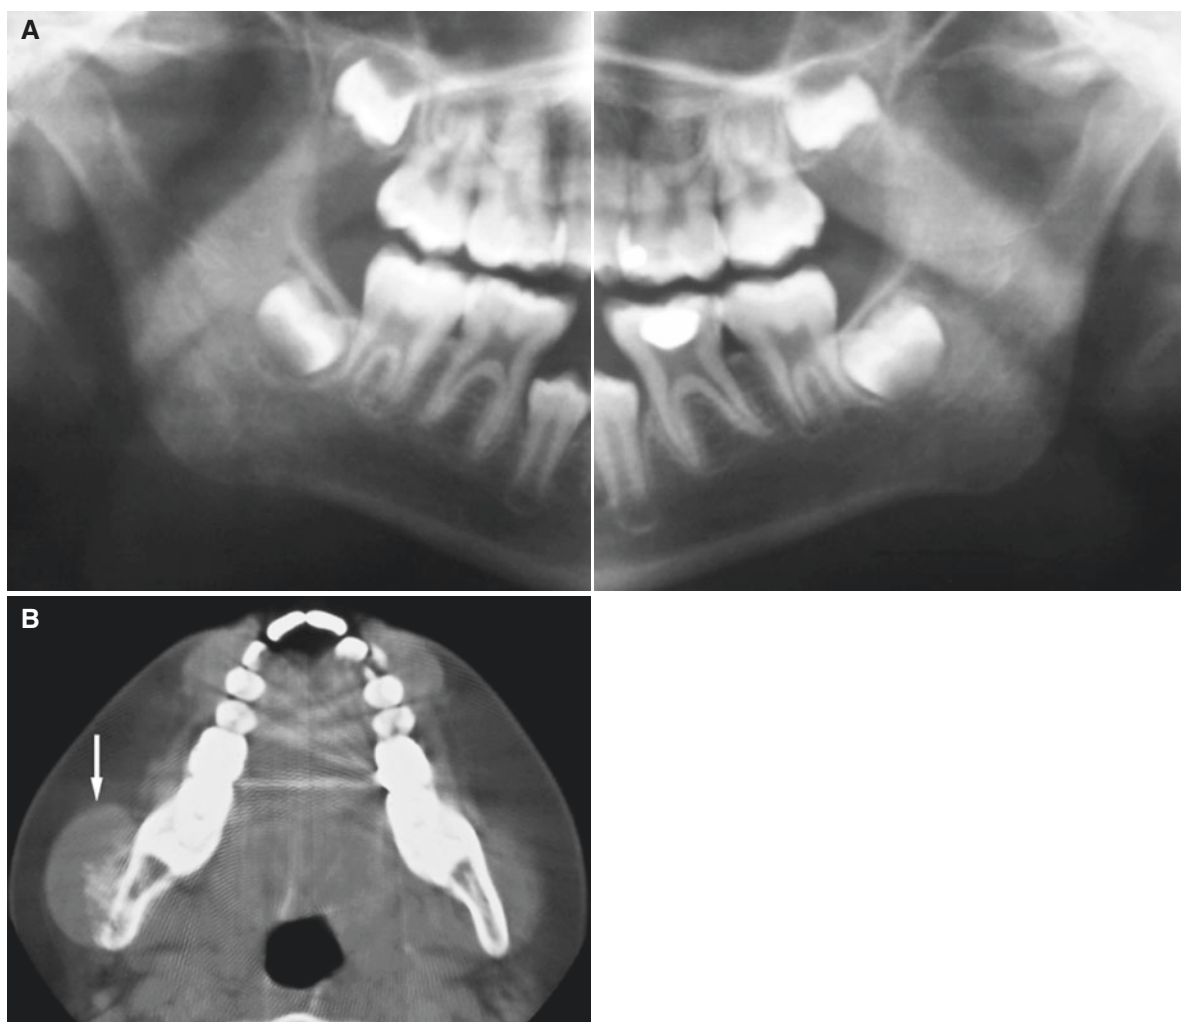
Ewing sarcoma, mandible; 10-year-old male with painless swelling at the right mandibular angle. (A) Panoramic view shows no abnormality. (B) Axial CT image shows soft-tissue mass and radiating bone production on buccal aspect (*arrow*)
